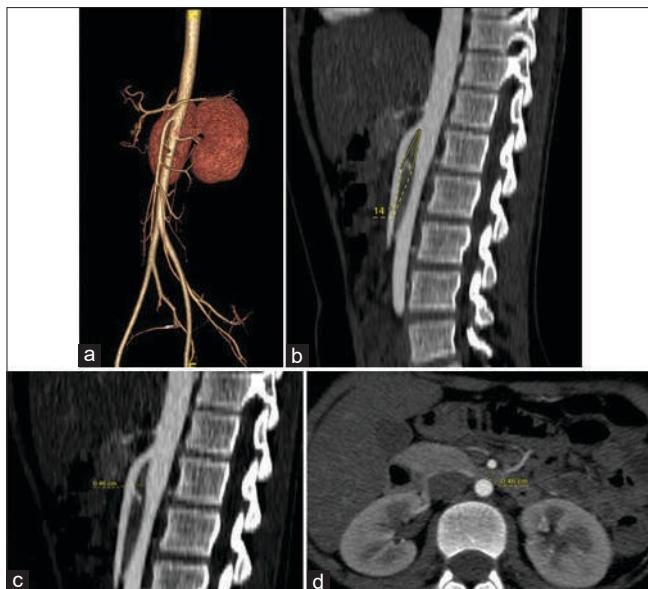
Contrast-enhanced computed tomography (CT) scan of abdomen: (a) CT angiogram of the abdomen showing aorta-superior mesenteric artery axis; (b) Reduced aortomesenteric angle (14°); (c) Reduced aortomesenteric distance (4.6 mm) in the sagittal plane; (d) Reduced aortomesenteric distance (4.6 mm) in horizontal plane
